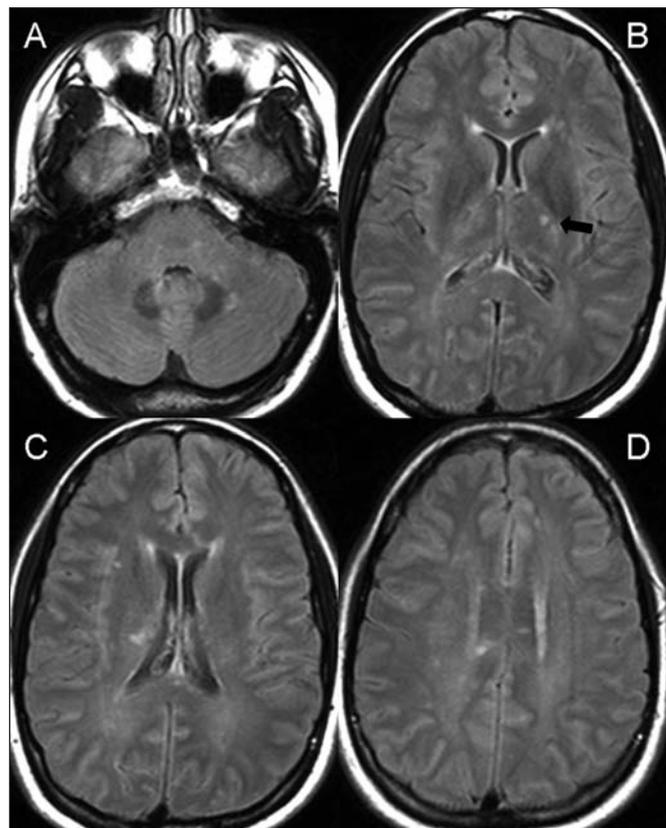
Axial FLAIR images (A-D) demonstrate multiple infratentorial and supratentorial white matter lesions, including lesions in the corpus callosum. Lesions are also seen in the deep grey nuclei (B, arrow, left thalamus).
